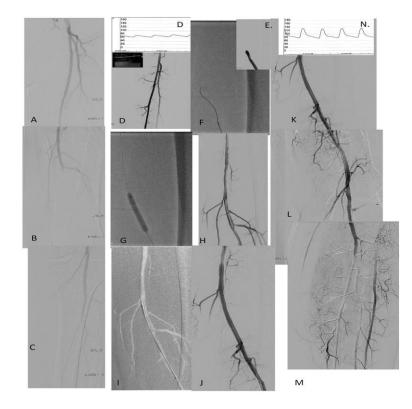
Femoro-popliteal artery intervention from TP access. (A-C) CTO of the right femoropopliteal artery. (D-E) Ultrasound-guided TP artery access, selective angiography and pedal pressure measurement. (F) Subintimal GW advancement. (G) Retrograde balloon dilatation after successful reentry. (H) Dissection requiring treatment. (I-J) Stent positioning and implantation. (K-M) Final angiography shows no residual stenosis or dissection. (N) TP pressure measurement after the intervention shows significant improvement.
